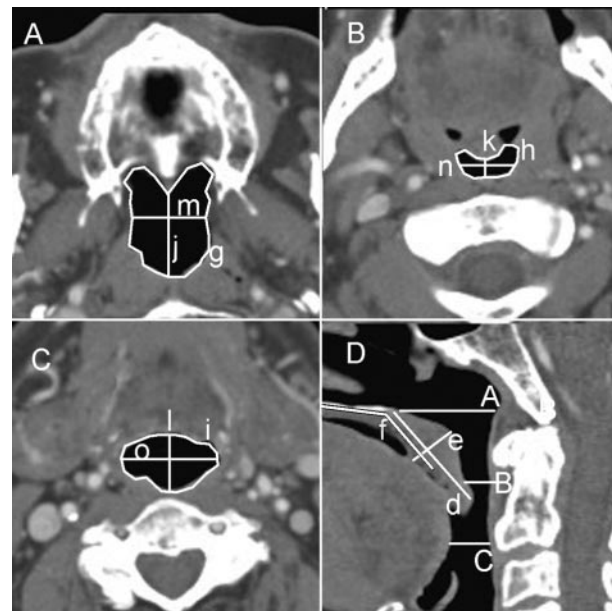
Distances, areas, and angle measured from the CT scan images. Top left, A: Hard palate level. Top right, B: Soft palate level. Bottom left, C: Level behind the root of the tongue. Bottom right, D: Sagittal projection of the pharynx. d = length of the soft palate and uvula, e = thickness of the soft palate, f = angle between the hard palate and the soft palate, g = area at the hard palate level, h = most narrow area, i = area behind the root of tongue, j = anteroposterior distance at the hard palate level, k = anteroposterior distance at the most narrow level; l = anteroposterior distance behind the root of the tongue, m = width at the hard palate level, n = width at the most narrow area, o = width behind the root of the tongue.
